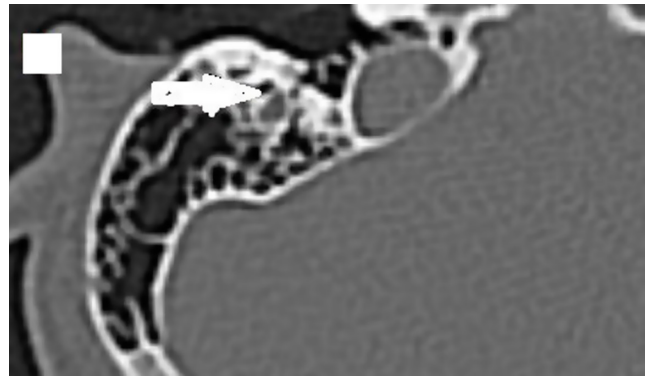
An axial cut of right temporal bone HRCT showing the presence of the Sentinel air cell around the facial recess (it was scored 0 marks). HRCT, high-resolution CT scan.
